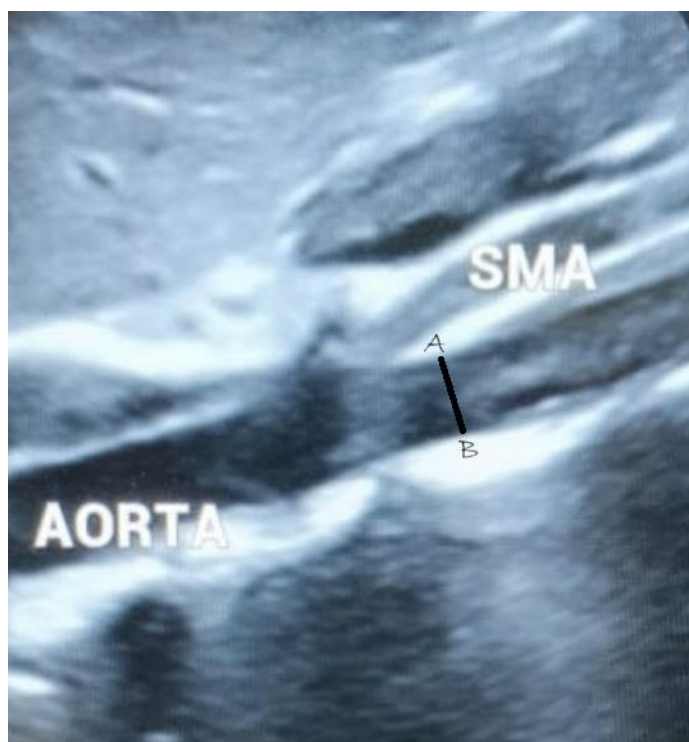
Sonographic diameter of the aorta (A-B)
